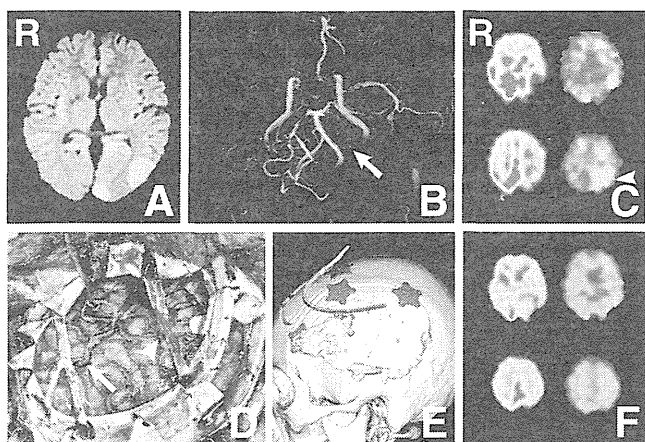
Radiological and intraoperative findings of a 38-year-old female who developed ischemic stroke. A: Diffusion-weighted magnetic resonance (MR) image demonstrating cerebral infarction in the left posterior temporal and occipital lobes at onset. B: MR angiogram revealing severe stenosis of the left posterior cerebral artery (arrow) as well as occlusive lesions in the bilateral internal carotid arteries. C: Preoperative oxygen-15 gas positron emission tomography (^{15}O -gas PET) scans showing marked reduction of cerebral blood flow in the entire left hemisphere (left column). Oxygen extraction is elevated in the left parieto-occipital lobe (right column, arrowhead). D: Intraoperative photograph showing a wide craniotomy exposing the posterior temporal and parietal lobes. The parietal branch of the superficial temporal artery (STA) is anastomosed to the angular artery to directly supply blood flow to the oxygen extraction-elevated area (arrow). The frontal branch of STA is anastomosed to the prefrontal artery (arrowhead). E: Postoperative three-dimensional skull computed tomography scan demonstrating the extent of craniotomy. F: Postoperative ^{15}O -gas PET scans showing improvement of the cerebral hemodynamics (left column) and oxygen metabolism (right column) in the operated hemispheres.
